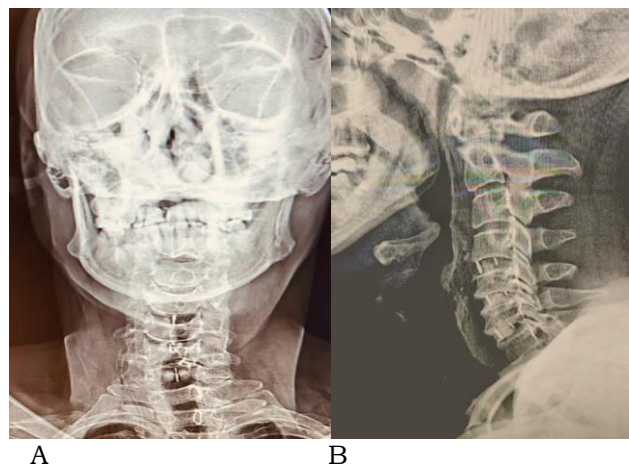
Follow up x-ray (6 months), A) AP view, B) Lateral view showing good fusion.
